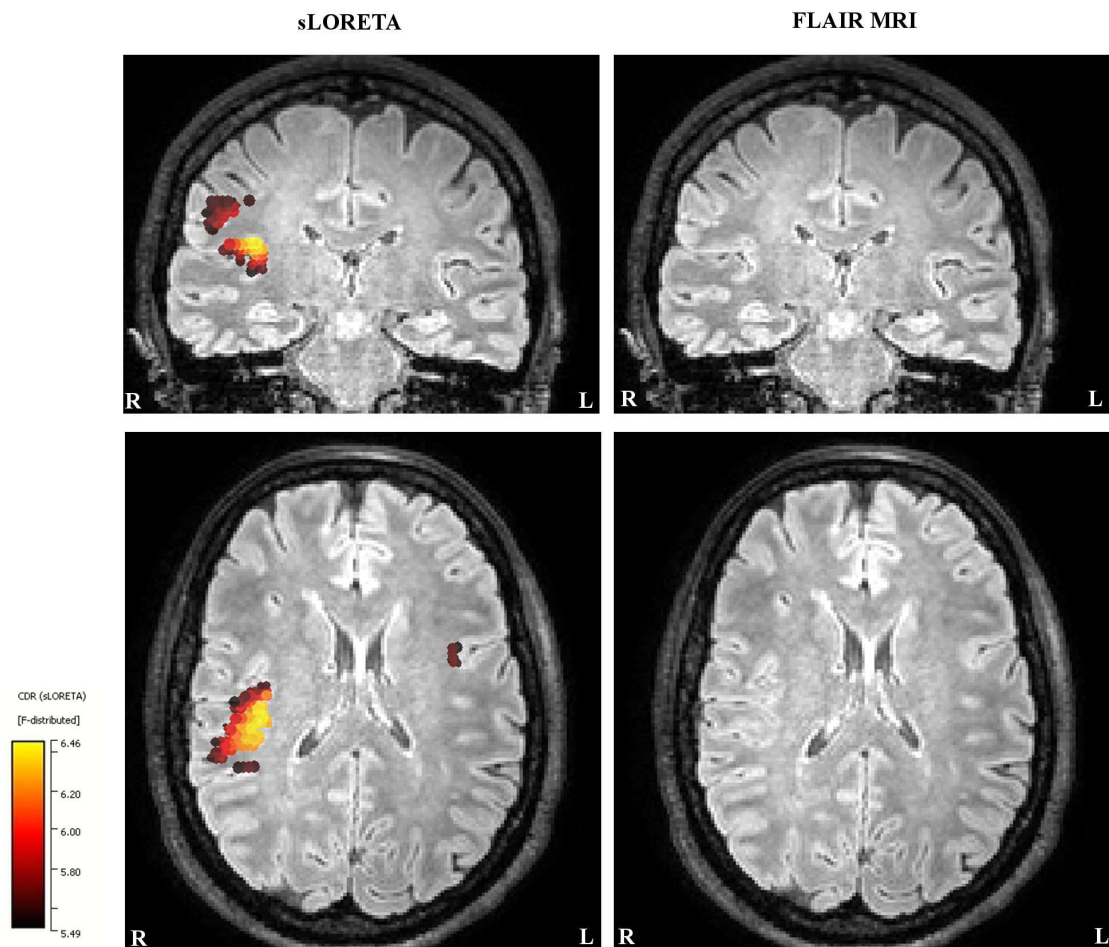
Source localizations at -23 ms, slices selected according to the right hemispheric activity. The sLORETA results registered to the FLAIR MRI are shown in the left column (only results obtained with a threshold of 85 % for the maximum F-value are shown). In the right column, the FLAIR image without the localizations is shown. The white letters on MRIs indicate the orientation (L: Left, R: Right, A: Anterior, P: Posterior).
